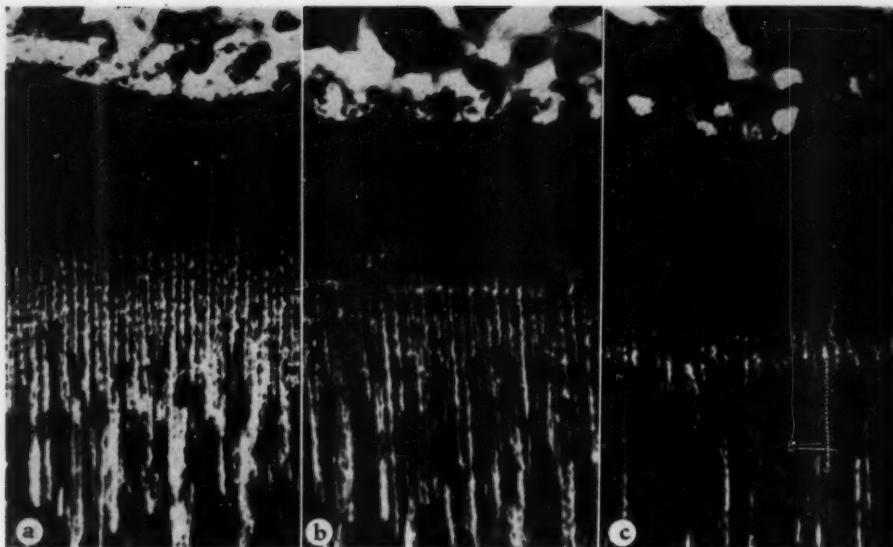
Radius. Small litter. Soft-x-ray technique for demonstrating mineral salts in ground sections (light areas).
